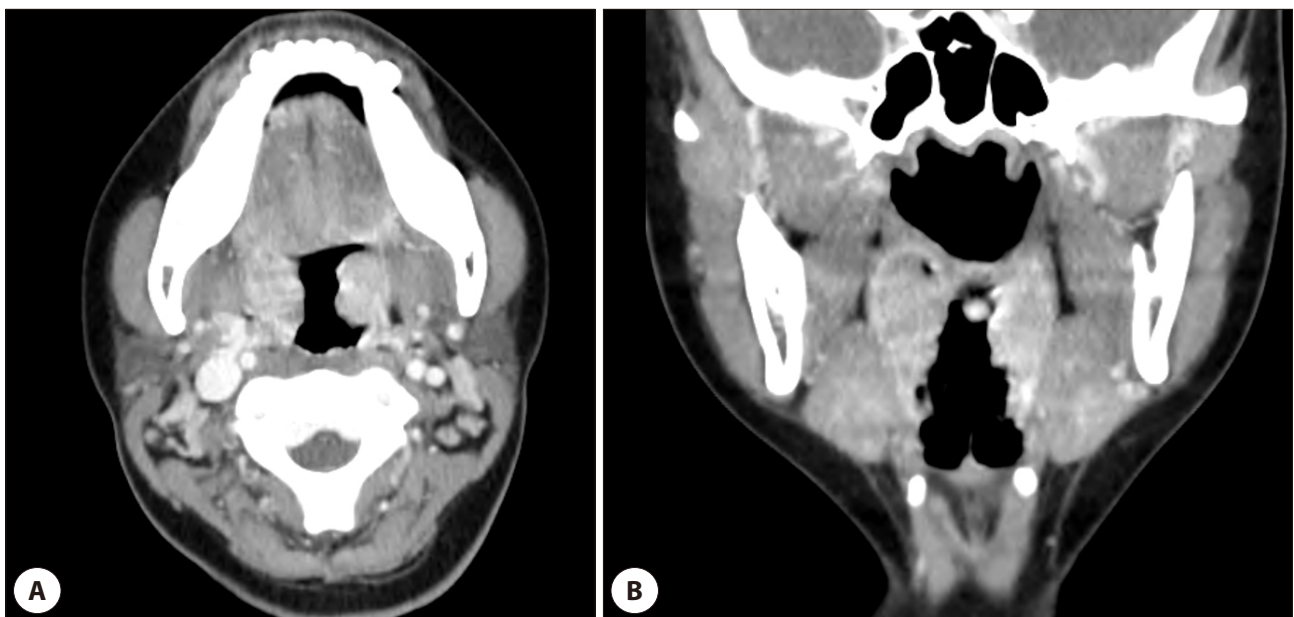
Contrast-enhanced neck computed tomography (CT) images. (A) Axial and (B) coronal views demonstrate diffuse, symmetrical enlargement and enhancement of both palatine tonsils and the surrounding pharyngeal wall. Despite the severity of the patient's symptoms and metabolic derangement, no rim-enhancing fluid collections or organized abscesses are identified in the peritonsillar or deep neck spaces.
